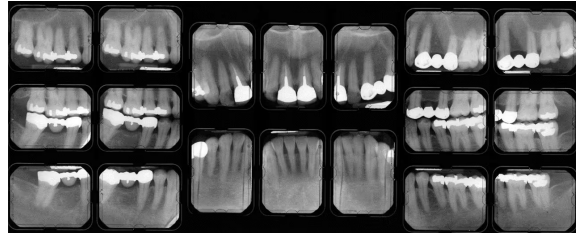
Posterior Bitewing Radiographs
